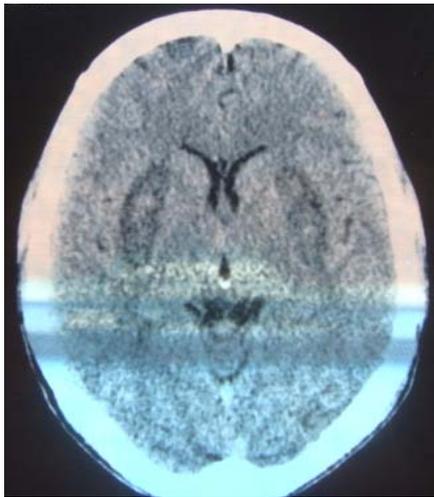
Computed tomography of case no 2 showing hypodensity in bilateral lentiform nucleus suggesting infarction.
